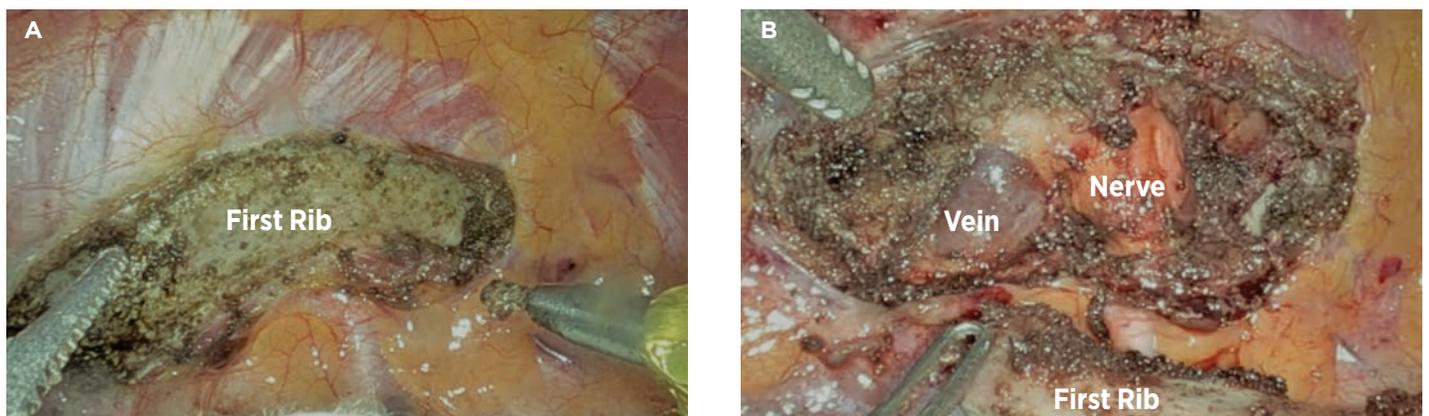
Robotic first rib resection for TOS. A. Transthoracic exposure of the first rib after division of the mediastinal pleura. B. View of the thoracic outlet after rib resection but prior to removal of the rib fragment. The subclavian artery and vein, brachial plexus, and scalene muscles are clearly visualized.
